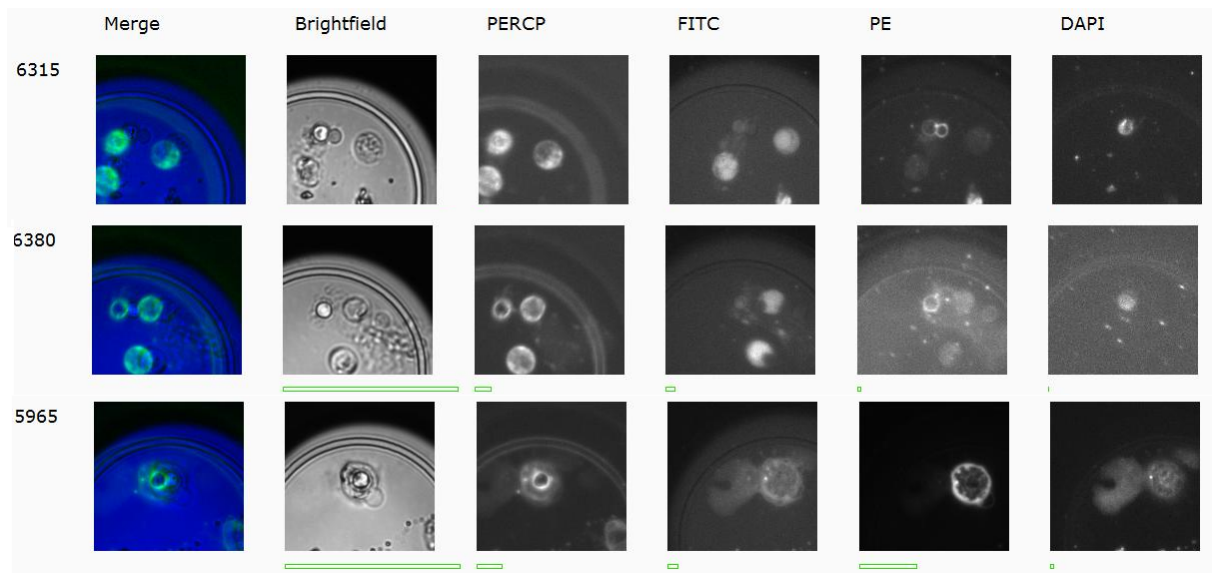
Examples of cells found in the chip. The top 2 rows are leukocytes and debris. The bottom row is a CTC. In total 2 CTC were identified. Lots of leukocytes were identified. From left to right. The well number. Merge: multiple channels. Brightfield, the chip, cells, and debris. PERCP: CD45. FITC: Calcein. PE: PSMA. DAPI: EpCAM.
